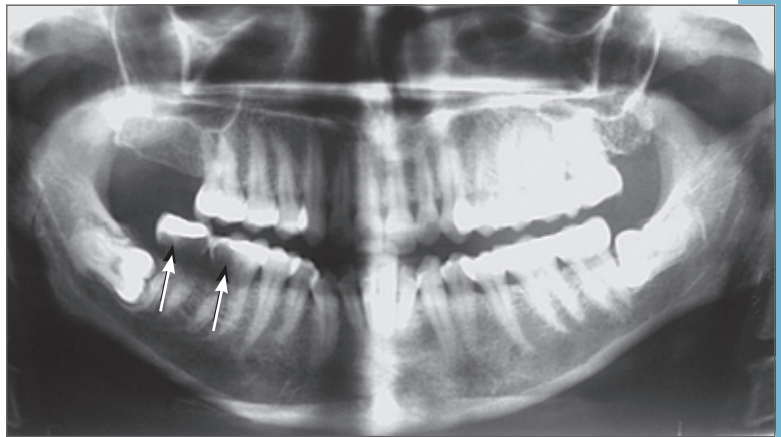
Panoramic radiograph prior to extraction showing bizarre cervical lesions (arrows).
